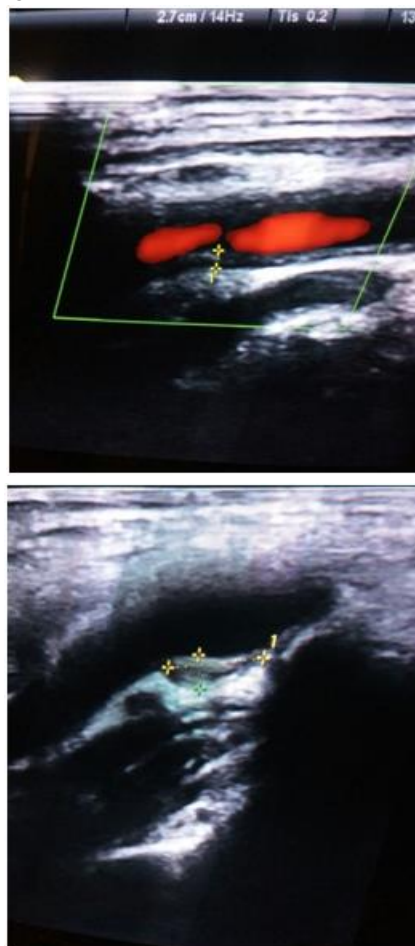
Doppler USG of carotid artery showing atherosclerosis plaque (measured using yellow cross)
